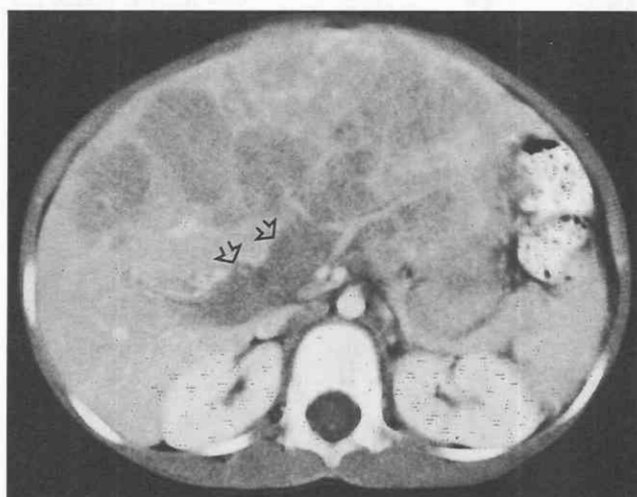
Hepatoblastoma. CT of the liver reveals multifocal hepatoblastoma with extension of tumor thrombus into the portal vein (*open arrows*).
